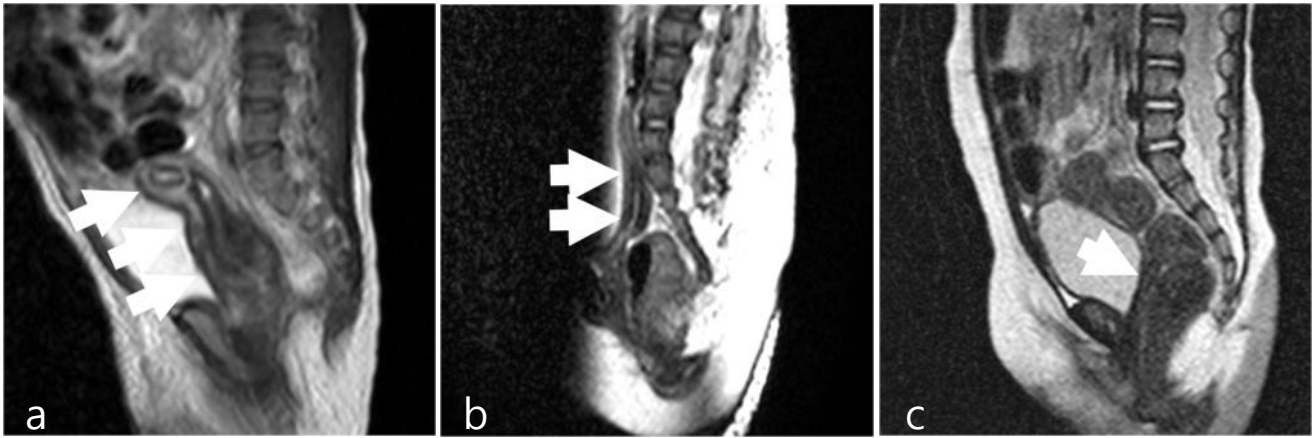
Uterine change on MRI according to age. a) 3 days old, b) 3 months old, c) 5 months old. A few months after birth, the uterus (arrows) becomes small until puberty. During this period, the recognition of uterine anomalies is difficult. In cases with suspicion of a Mullerian duct anomaly, examination should be performed soon after birth.
